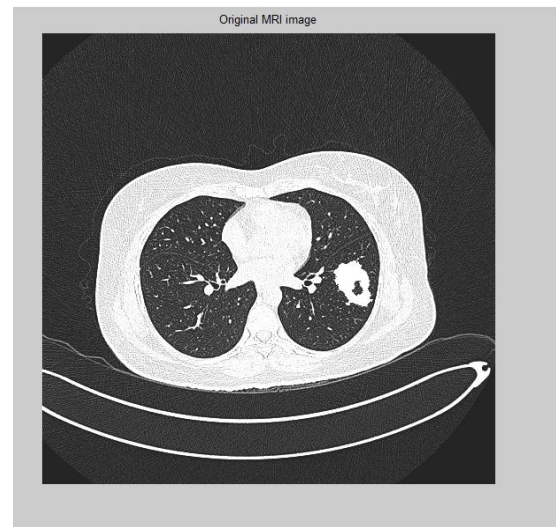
ORIGINAL MRI IMAGE
